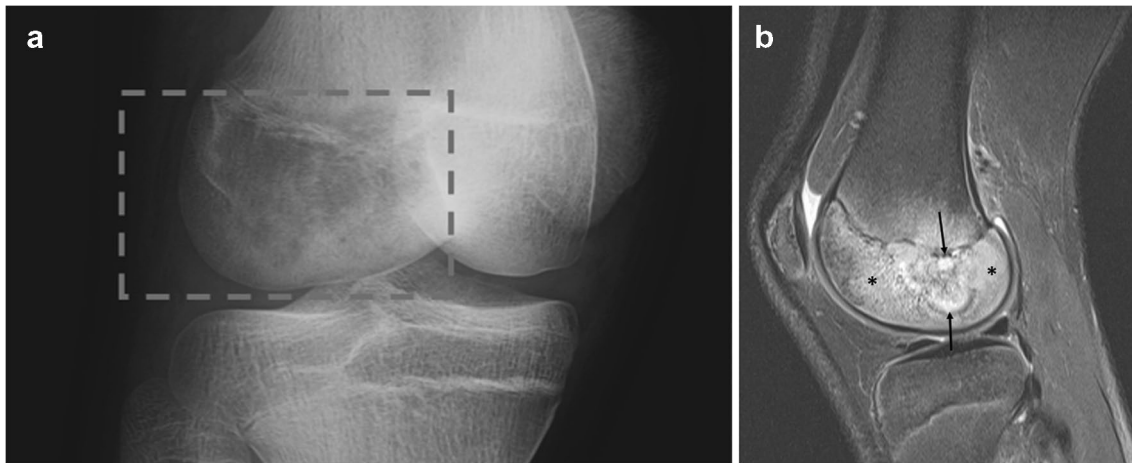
Images of a 14-year-old boy with continuous right knee pain in the preceding 3 months, increasing during weight bearing. Magnification of conventional radiography, anteroposterior-oblique view, of the right knee (a), shows a lytic lesion at the distal epiphysis of the femur (lateral condyle, *dotted square*) with ill-defined margins.
